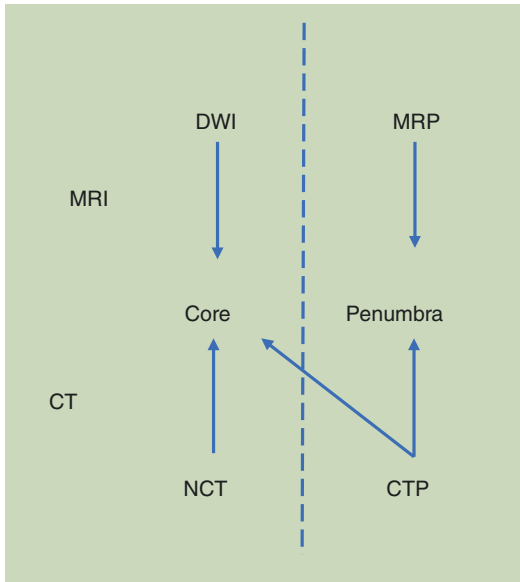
Prediction of core from CT and MRI. MRI predicts core using structural imaging (DWI) and perfusion using MRP. In contrast, CTP uses both structural and perfusion imaging to predict core
